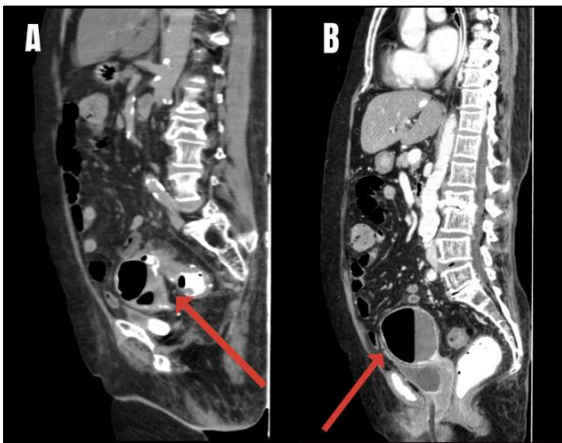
CT abdomen sagittal view (A) Plain scan showing contrast leak from sigmoid colon into the uterine cavity (red arrow) (B) Contrast scan showing pyometra (red arrow).
